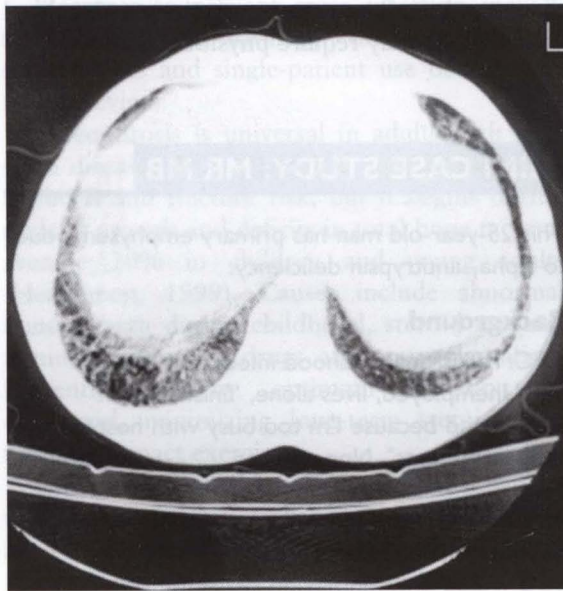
CT scan of Mr MB at a lower level
